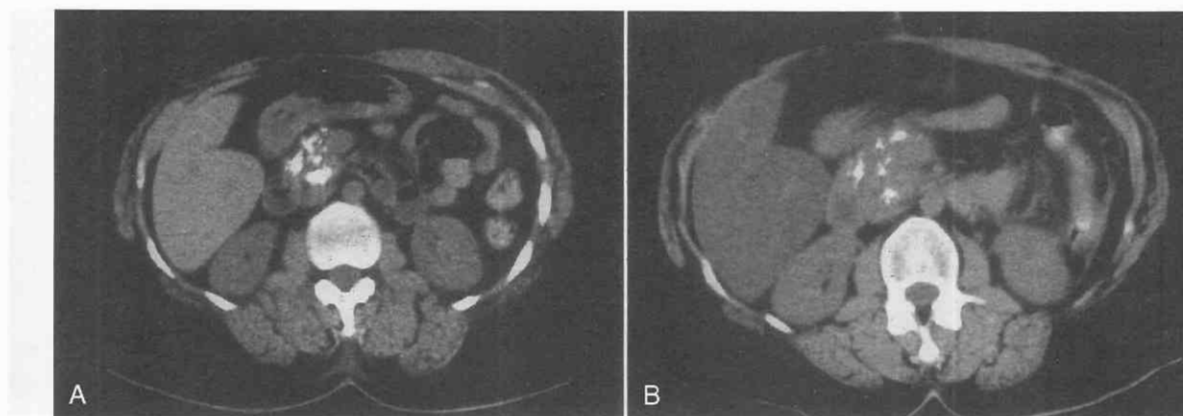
A, CT scan obtained before resumption of inflammation shows dense calcification within the head of the gland. B, Subsequent scan shows enlargement of the head of the gland, demonstrating that the calcifications have moved peripherally as the gland has enlarged.
